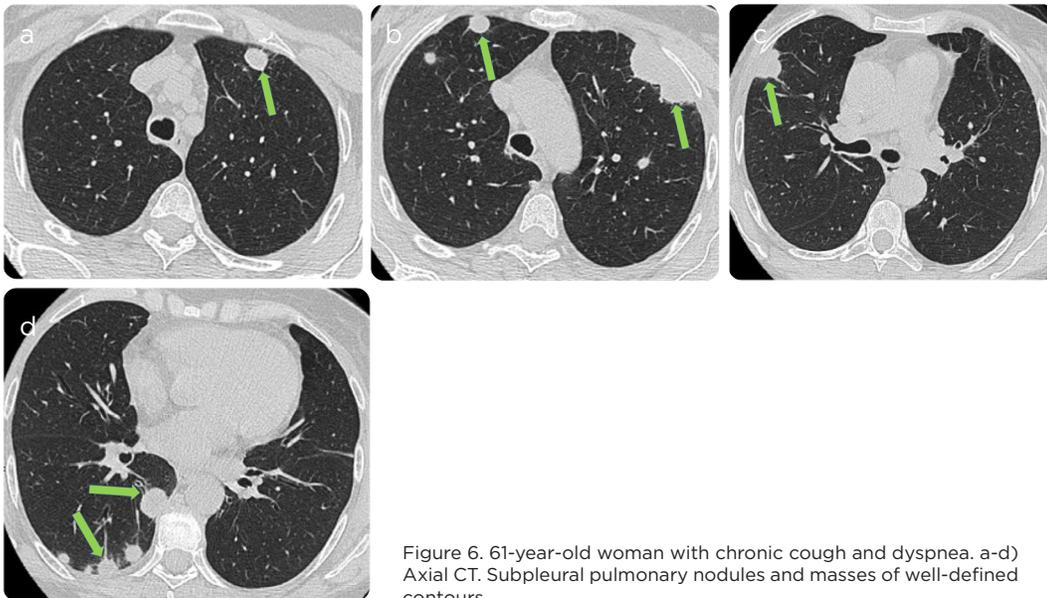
61-year-old woman with chronic cough and dyspnea. a-d) Axial CT. Subpleural pulmonary nodules and masses of well-defined contours.
